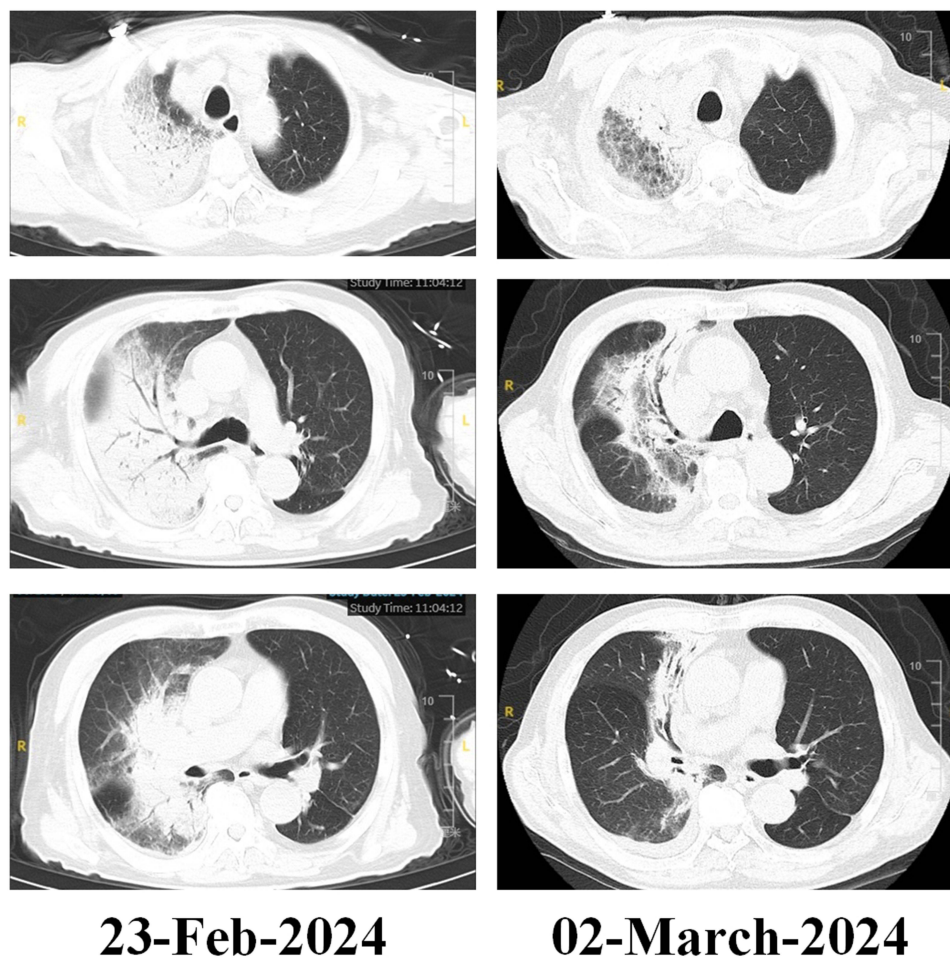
On February 23, 2024, the patient underwent a chest CT scan upon admission, revealing consolidation with the air bronchogram sign in the right upper, middle, and lower lobes of the lung. Subsequent follow-up imaging on March 2, 2024, showed a significant reduction in infectious lesions in the right lung.
